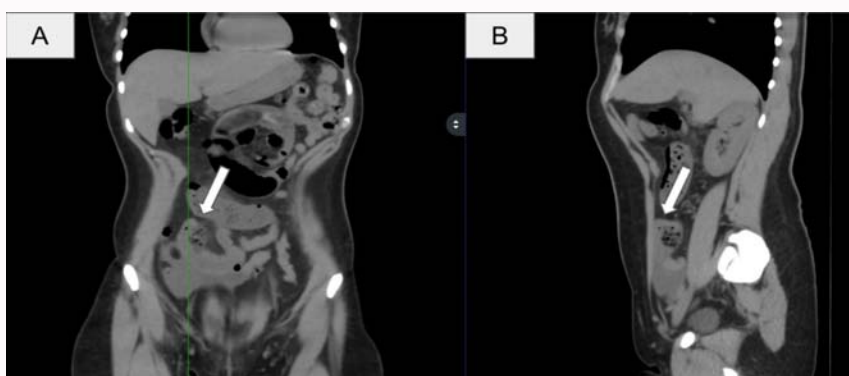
Computed tomography of the abdomen. (A) Coronal reconstruction demonstrating dilated small bowel loops with findings suggestive of intestinal subocclusion. (B) Sagittal reconstruction showing the transition zone, with the arrow indicating the probable site of obstruction.
